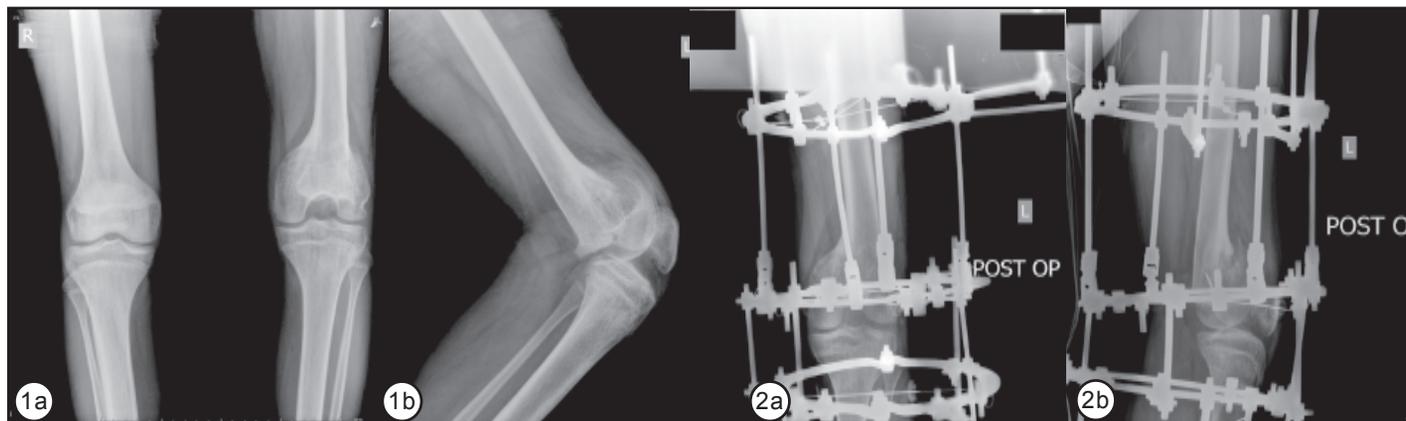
Pre-operative X-ray- malunited and completely anteriorly displaced distal femoral condyles.
